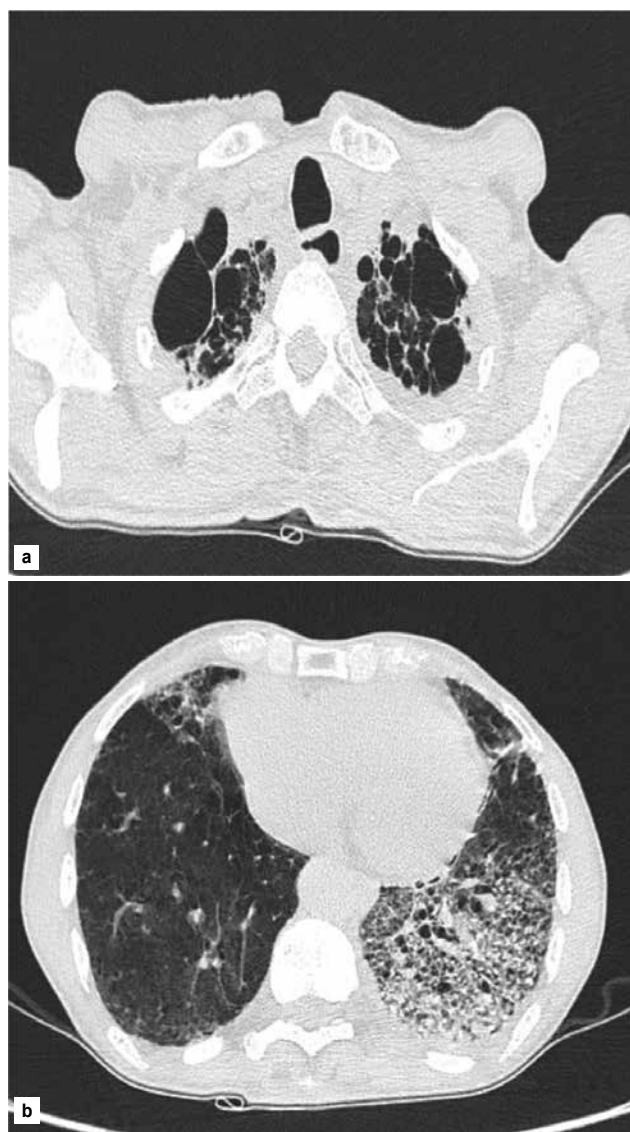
HRCT of the chest demonstrating (a) bilateral apical emphysematous changes (b) interlobular septal thickening in the left lingula and left lower lobe with consolidation in the left lower lobe.
